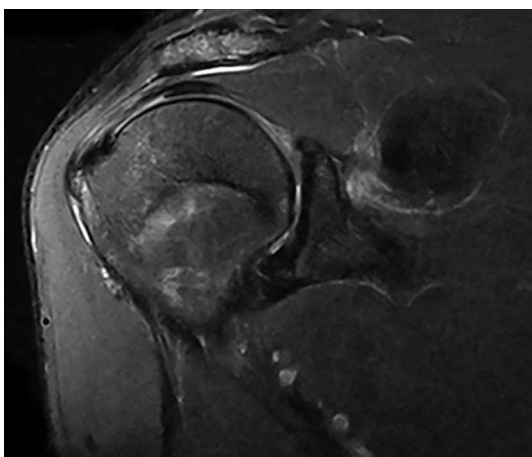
Eleven months after injury, coronal T2-weighted fast spin-echo magnetic resonance imaging with fat suppression shows scarring and resolution of humeral avulsion of glenohumeral ligament lesion.
